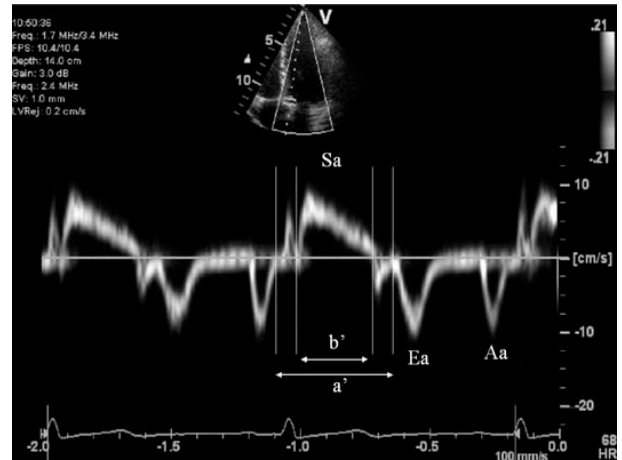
The myocardial performance index determined by Tissue Doppler Imaging (Tei-TDI) defined as the sum of isovolumetric contraction and relaxation durations divided by ejection time and calculated as (a' - b')/b' ratio (a' = the time interval during diastole and b' = the duration of the systole Sa-wave).
